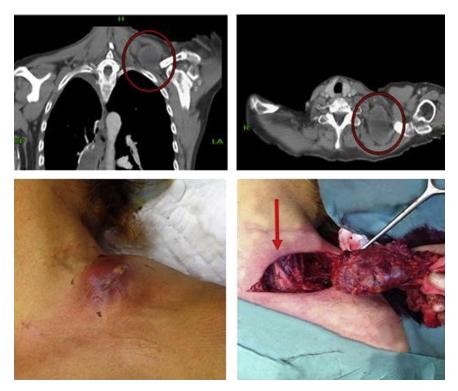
CT imaging of the supraclavicular lymph node (within the red circles) (above) and intraoperative pictures of the lesion and localization (the brachial plexus indicated with a red arrow) (below).
